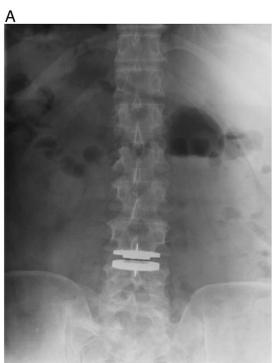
Plain radiographs of lumbar spine in anteroposterior (A) and lateral (B) views 6 months after TDA.
